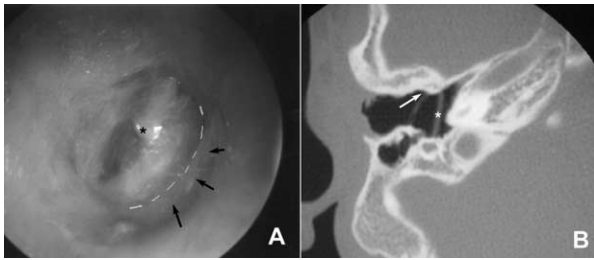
(A) Transcanal photograph of postoperative healed TTMR using described technique. *Dotted white line* denotes anterior neotympanic margin without blunting and good surface area. *End of malleus handle. *Small black arrows* delineate anterior bony ledge. (B) Postoperative axial CT of a different patient. Note the nonblunted anterior angle of the neotympanum (*white arrow*). *A sheet of silicone that was placed deep to the initial reconstruction in the mesotympanum. This patient had extensive congenital cholesteatoma and recently underwent a staged TORP.
